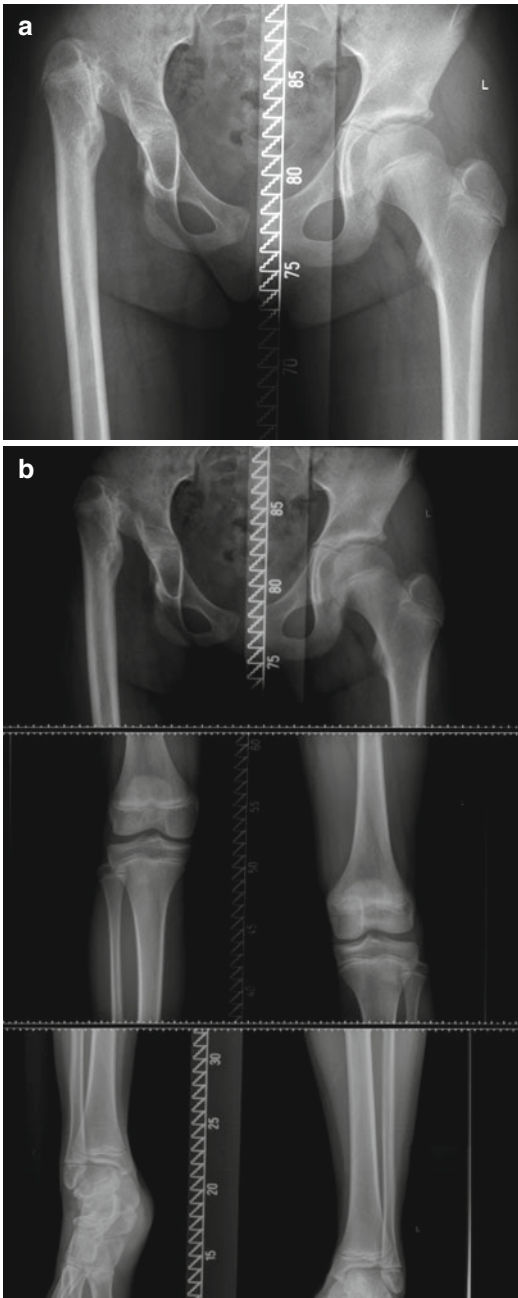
Limb length discrepancy from septic arthritis or osteomyelitis of the hip in infancy. Radiographs demonstrating complete destruction of the femoral head and neck with secondary dislocation from untreated infection in infancy. The AP pelvis radiograph (a) demonstrates the proximal dislocation along with the destruction of the proximal femoral epiphysis and metaphysis. The scano-gram (b) demonstrates the leg length discrepancy
